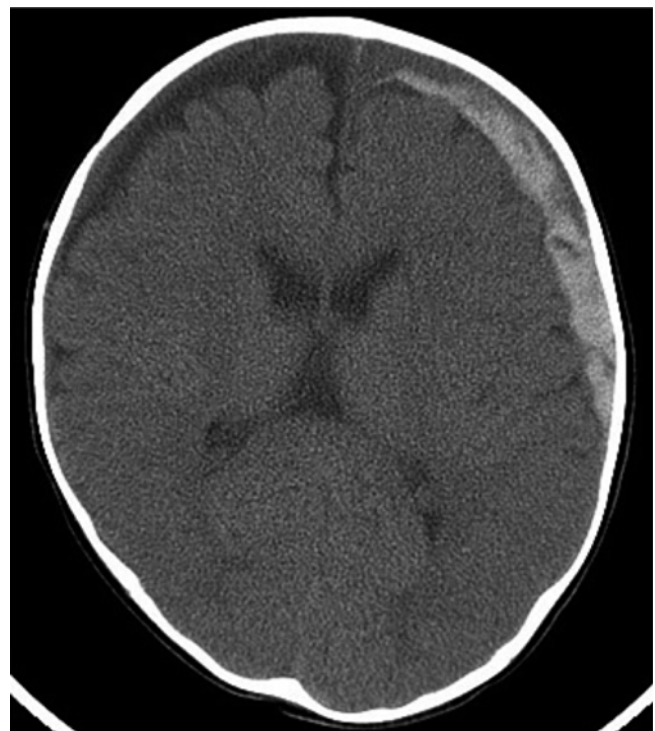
CT appearance of a subdural hematoma
